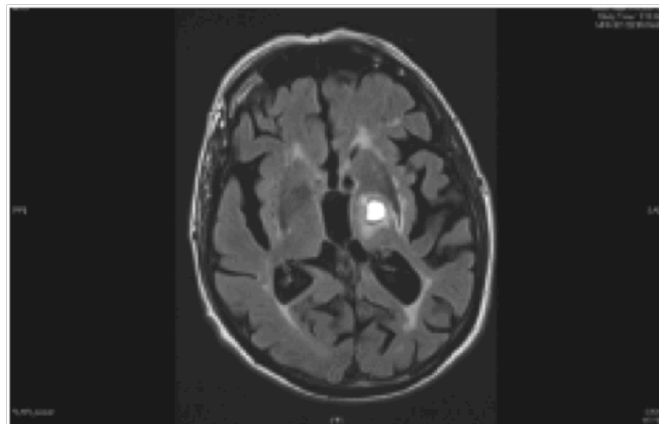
Axial FLAIR image of the lesion
